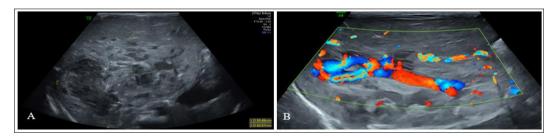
A massive hepatic mass in segments VIII, VII, IVa, V, and I, with an oval shape (A) and lobulated borders. It exhibited a heterogeneous echotexture, containing vascular lakes that were highlighted on color Doppler imaging (B).
